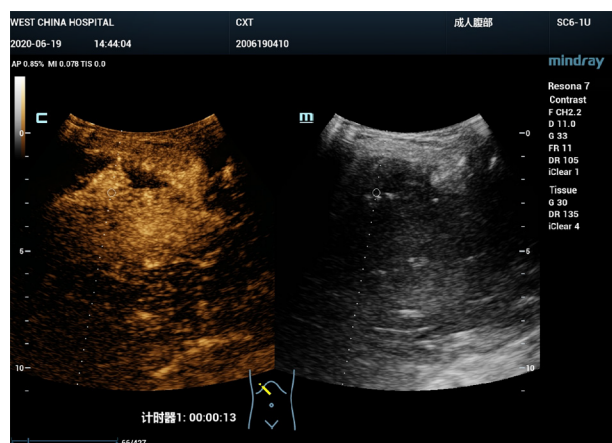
Second-time intravenous contrast-enhanced ultrasound demonstrated that the right subphrenic mass (6.0 cm × 1.7cm) showed a similar enhancement pattern to the first-time contrast-enhanced ultrasound.
